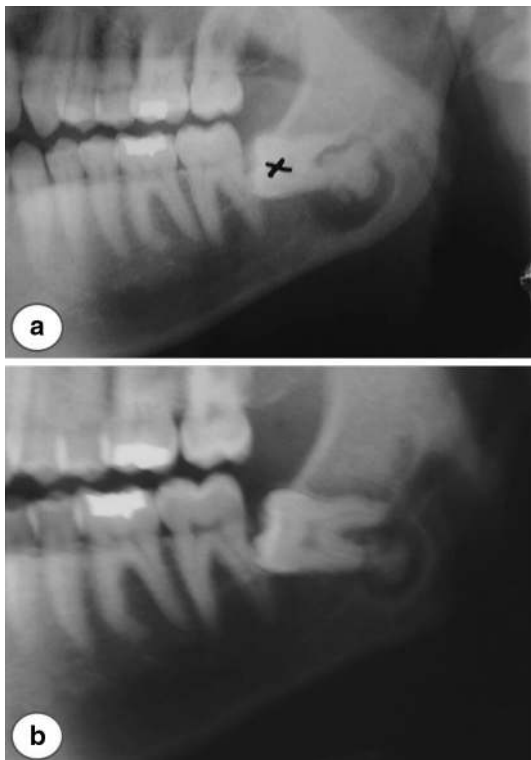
Case 1. a A circumscribed radiolucency with central radiopacity is associated with the roots of the impacted left mandibular third molar. b A panoramic radiograph taken 4 years earlier showed the presence of a slightly smaller and less calcified lesion
